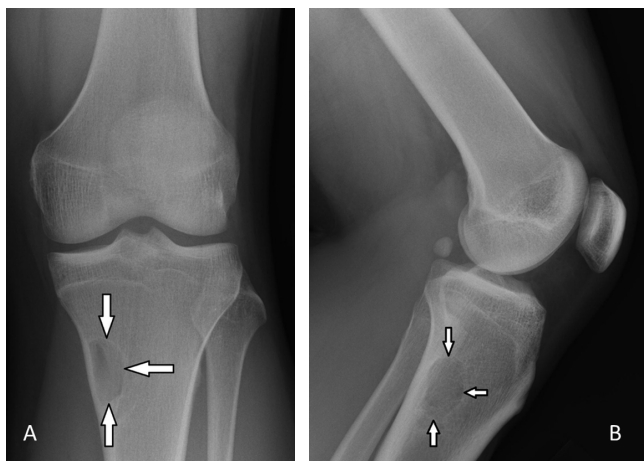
A) Frontal and B) lateral radiographs of the left knee show an eccentric radiolucent lesion with a thin sclerotic rim (arrows) located in the proximal metadiaphysis of the left tibia.
